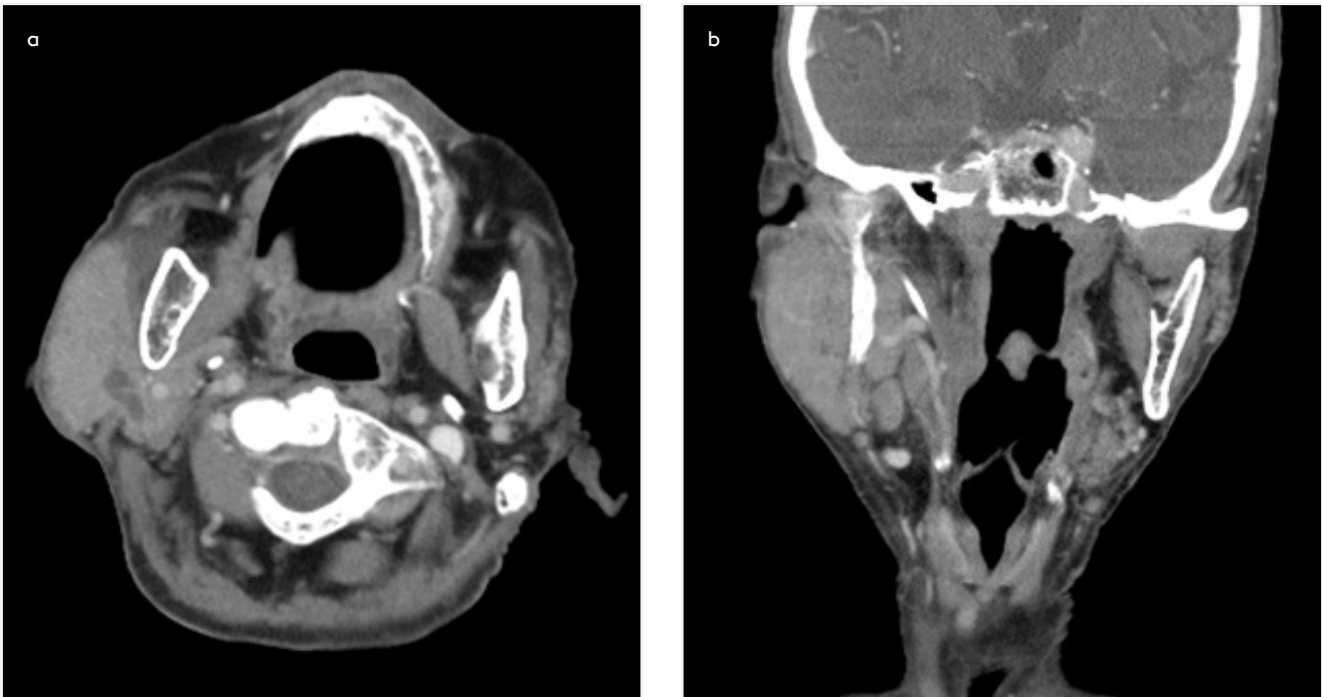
a, b. A 81-year-old female patient with primary EHNLS (NHL, Marginal zone lymphoma, stage IE) in right side parotid gland, received chemoradiotherapy and disease free more than 2 years. Contrast-enhanced axial (a) and coronal (b) CT images show a well-defined, regular shaped, moderately homogeneous enhanced soft tissue mass involving the right side parotid gland.
